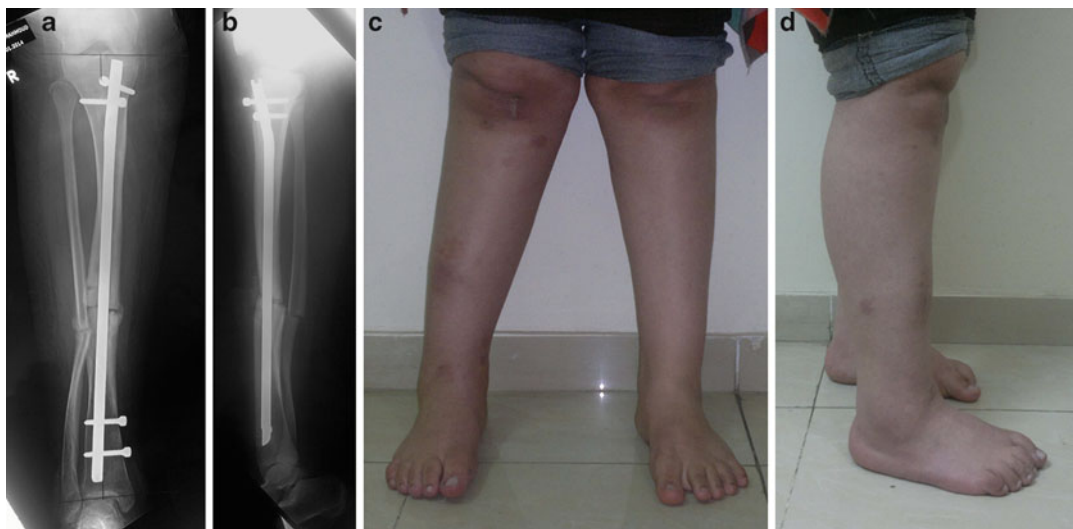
(a, b) Follow-up radiographs show healing of the osteotomy and graft incorporation. The mechanical axis of the tibia is within normal limits. (c, d) Clinical photos show full weight bearing and good functional outcome; however, a knock-knee deformity is apparent
